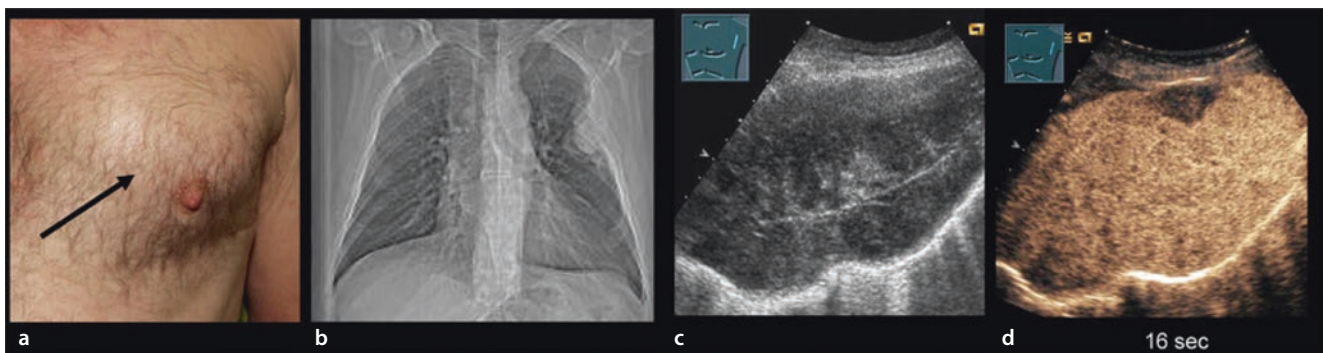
a Man with a space-occupying lesion in the chest wall (arrow). b On the chest X-ray, a space-occupying lesion is seen in the apical lateral aspect on the left side. c The B-mode image shows a large
